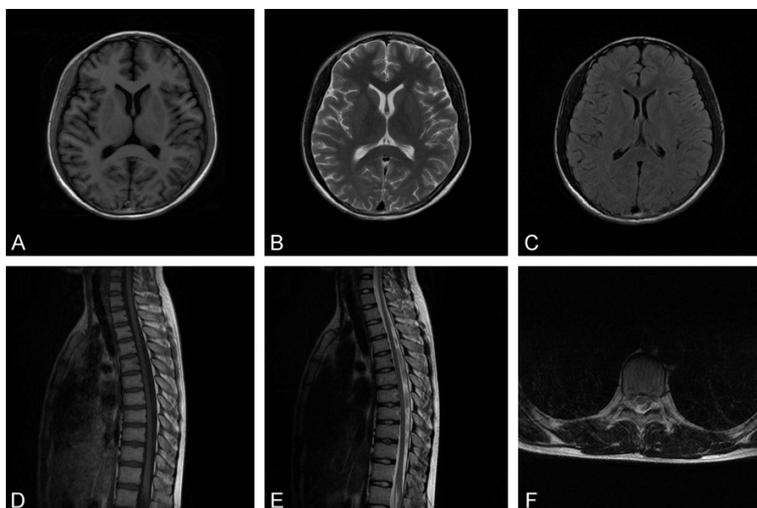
Follow-up MRI of brain (A-C) and spinal cord (D-F) showed radiological conditions were recovered completely.
